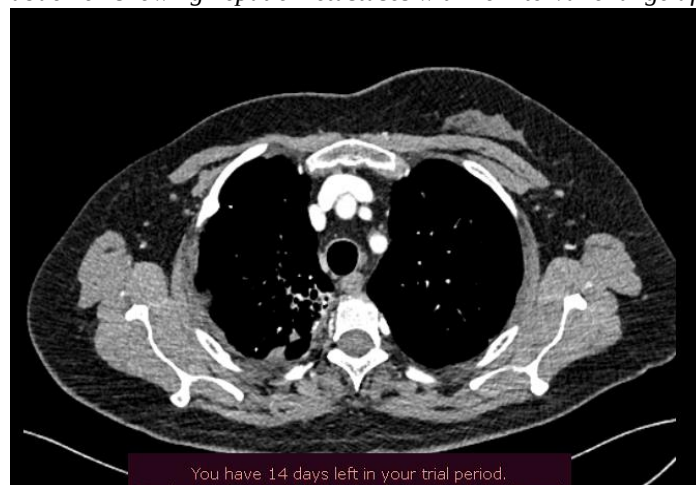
Thoracic CT showing no progression.
